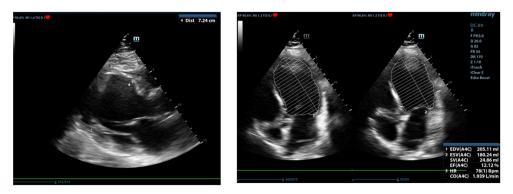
a.2. Dilated LV and severe systolic dysfunction in a case of alcoholic dilated cardiomyopathy (left: EDD=7,24 cm; 2D, parasternal long axis view; right: increased teledyastolic volume EDV=205 ml, decreased stroke volume (24.8 ml) and cardiac output (1.9 L/min); 2D, apical 4-chambers view, Simpson's biplane method)
